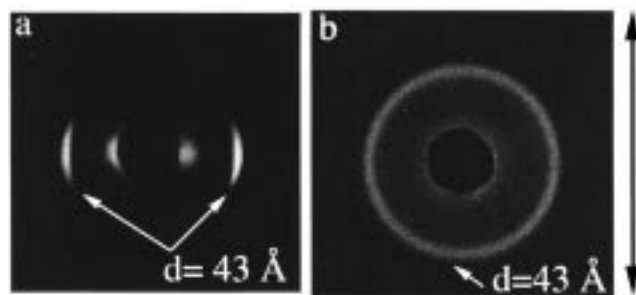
SAXD patterns of the PLD films cast from chloroform solutions containing 1 vol % (a) and 10 vol % (b) trifluoroacetic acid. The X-ray beam was parallel to the plane of the films. The arrow indicates the orientation of the film.
